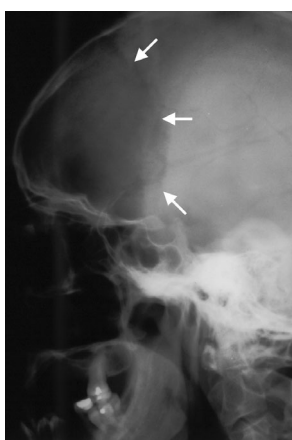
Lateral skull radiograph (from another patient). The arrows point to an osteolytic area in the skull known as osteoporosis circumscripta.
